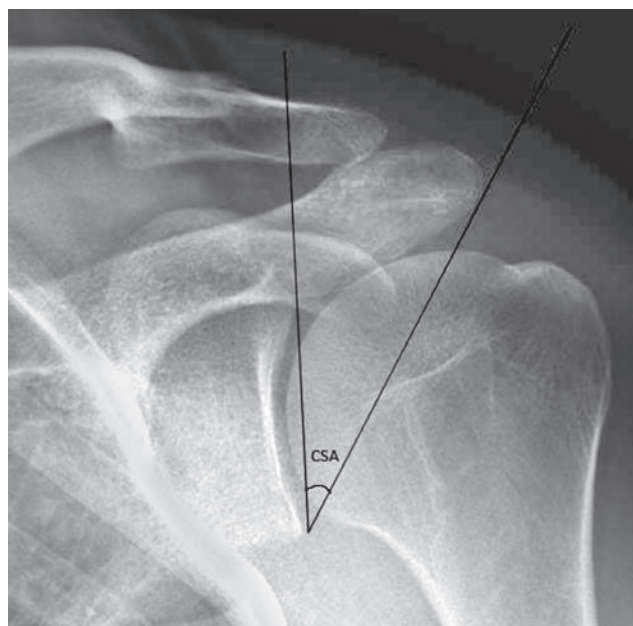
X-ray showing the CSA measurement (angle between the line joining the inferior and superior of the glenoid and the line joining the inferolateral acromion and the inferior of the glenoid).
